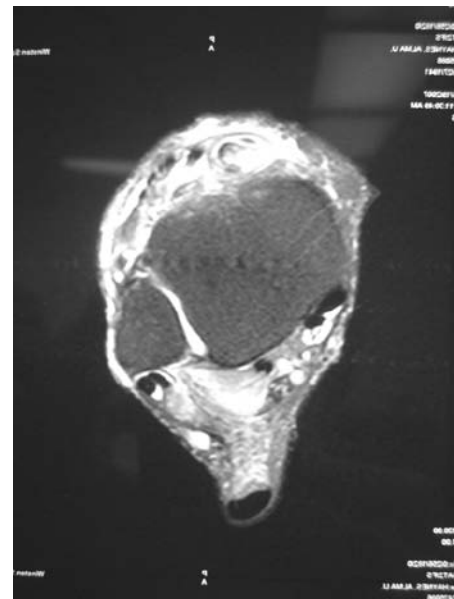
A transverse T2-weighted MRI image of a ruptured tibialis anterior tendon.
